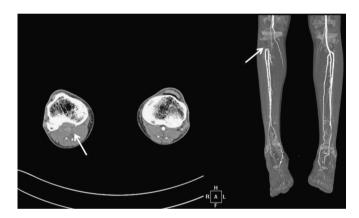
Axial and coronal images of CT angiography. CT angiography shows a total occlusion of the right popliteal artery (arrow).
